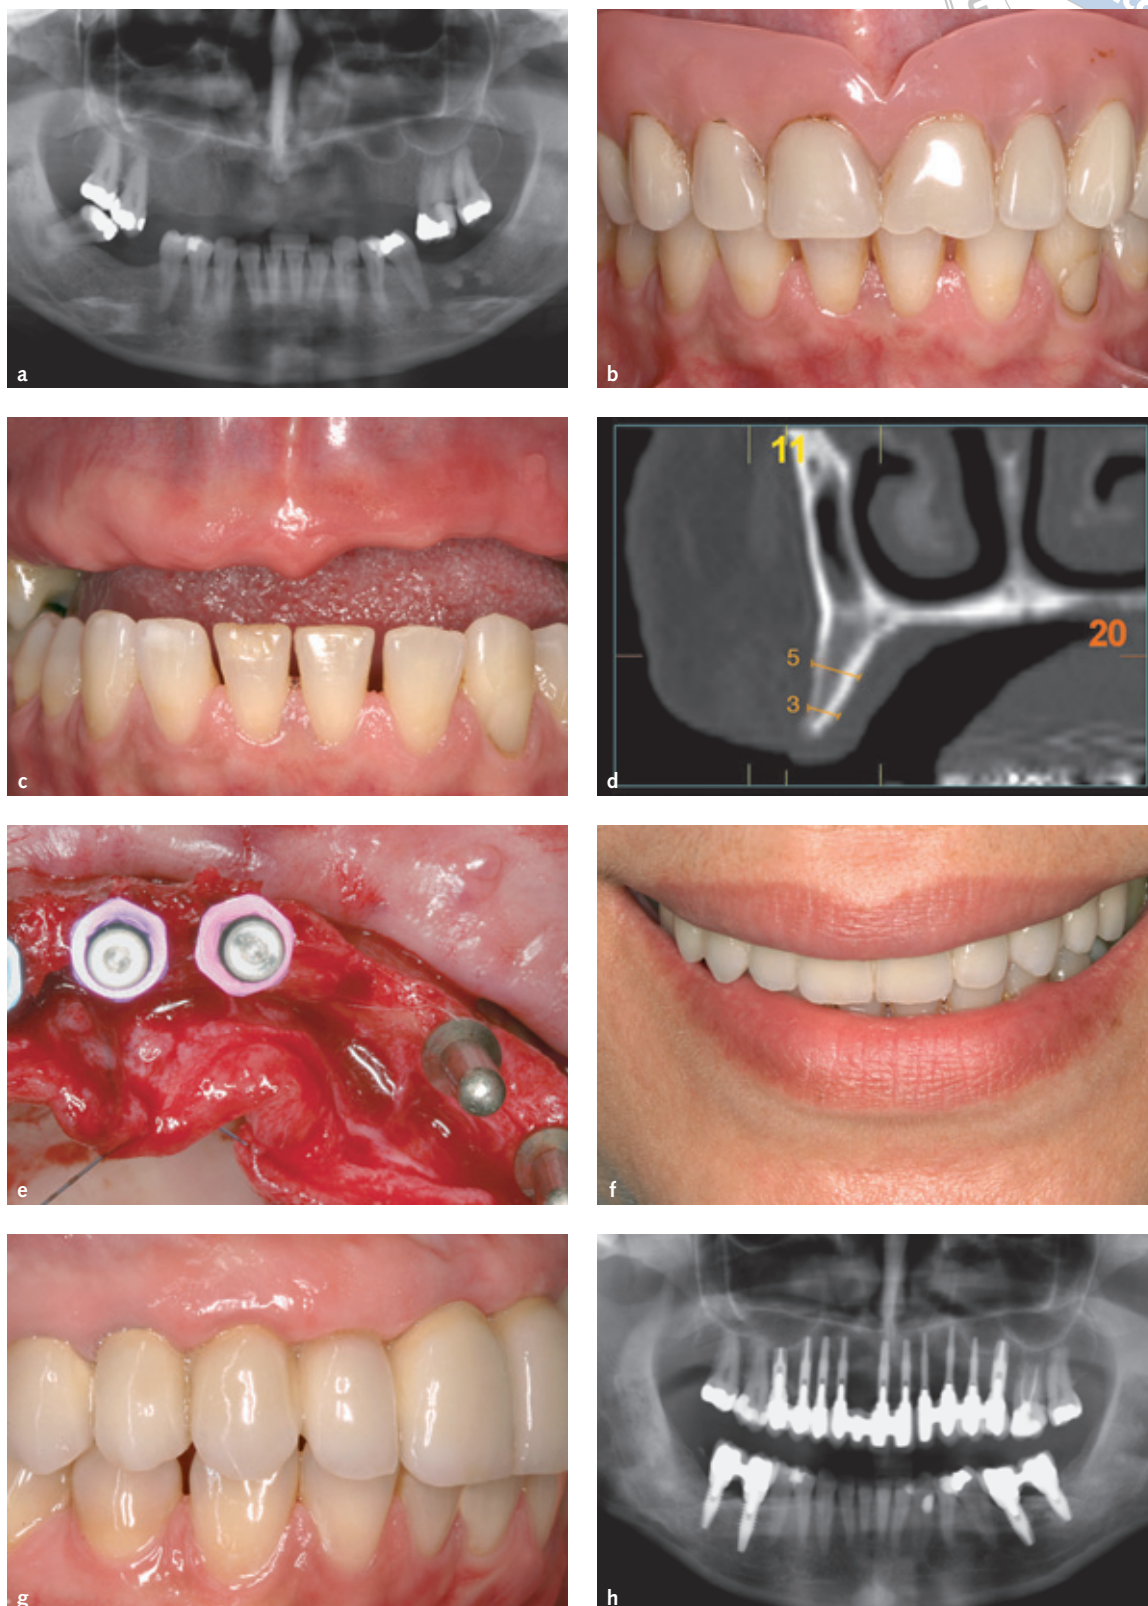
Example of another case involved in the study. (a to d) Panoramic radiograph of a 58-year-old patient with partial edentulism. The ridge ranged between 3 and 4 mm. (e) Implants were placed after ridge expansion. Some Tiny® implants were used as transitional implants. (f) Provisional prosthesis. (g) When placing the definitive prosthesis, all implants were osseointegrated and the transitional implants were maintained. (h) Final situation of the patient 4 years after implant placement.
